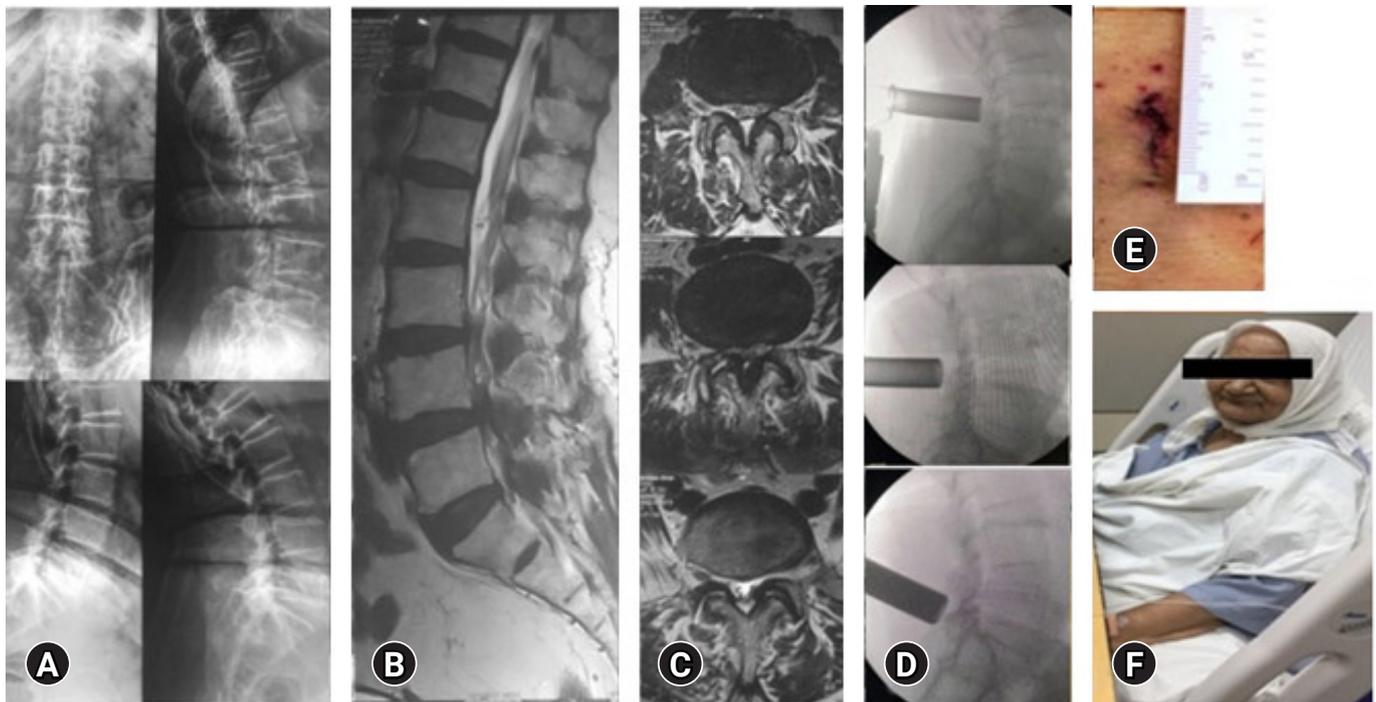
A 75-year-old morbidly lady (case 27) with L3-L4, L4-L5 and L5-S1 stenosis: AP and lateral X-rays (A), MRI sagittal films (B), MRI axial films (C). Fluoroscopic sequential docking of the tube at all three levels (D) and post-operative scar measuring 18 mm (E). Patient lying comfortably in the bed on the evening of the surgery (F).
